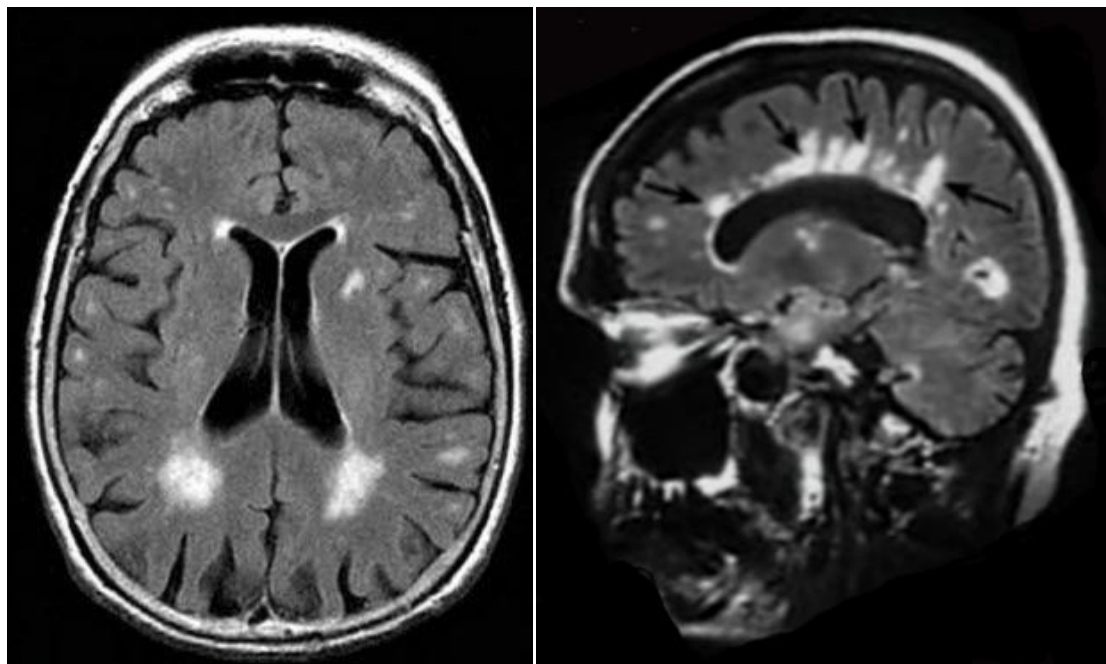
MS FLAIR images. The plaques are very obvious on the transverse (left) and sagittal (right) (arrows) images.
